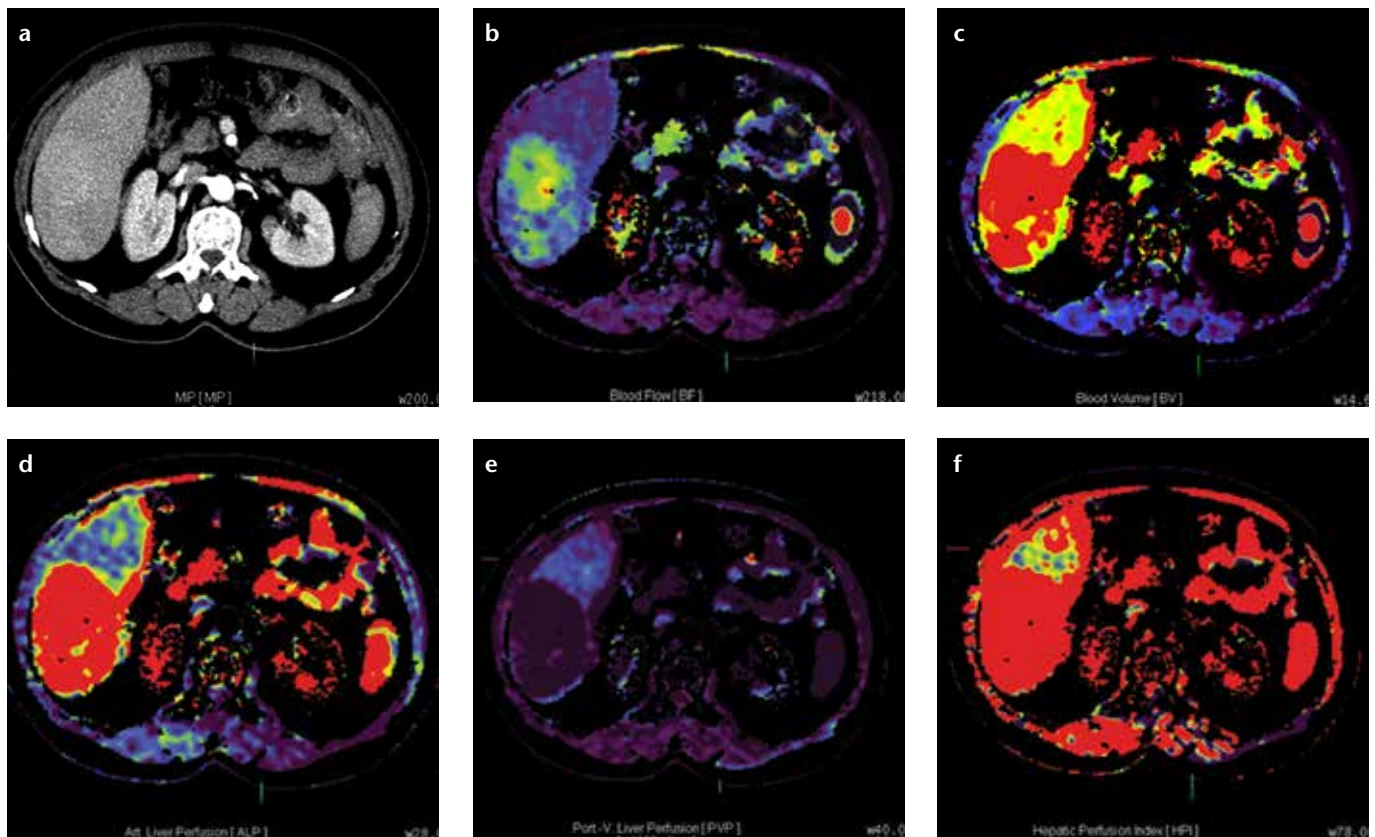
a–f. Axial perfusion images (a) and functional CT perfusion map (b–f) of a 53-year-old man with hepatocellular carcinoma before chemoembolization. The tumor shows an increased hepatic arterial perfusion and decreased hepatic portal perfusion compared with the normal parenchyma.
